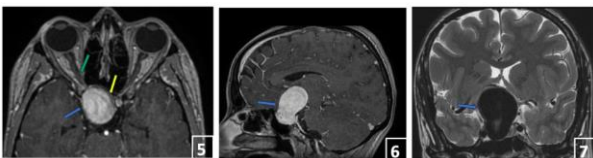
Axial T1-weighted enhanced brain MRI showing a giant right internal carotid aneurysm (blue arrow) measuring 45,83 mm at its greatest axis, the optic nerves are normal, the chiasm is stretched anteriorly (yellow arrow) by the aneurysm.
